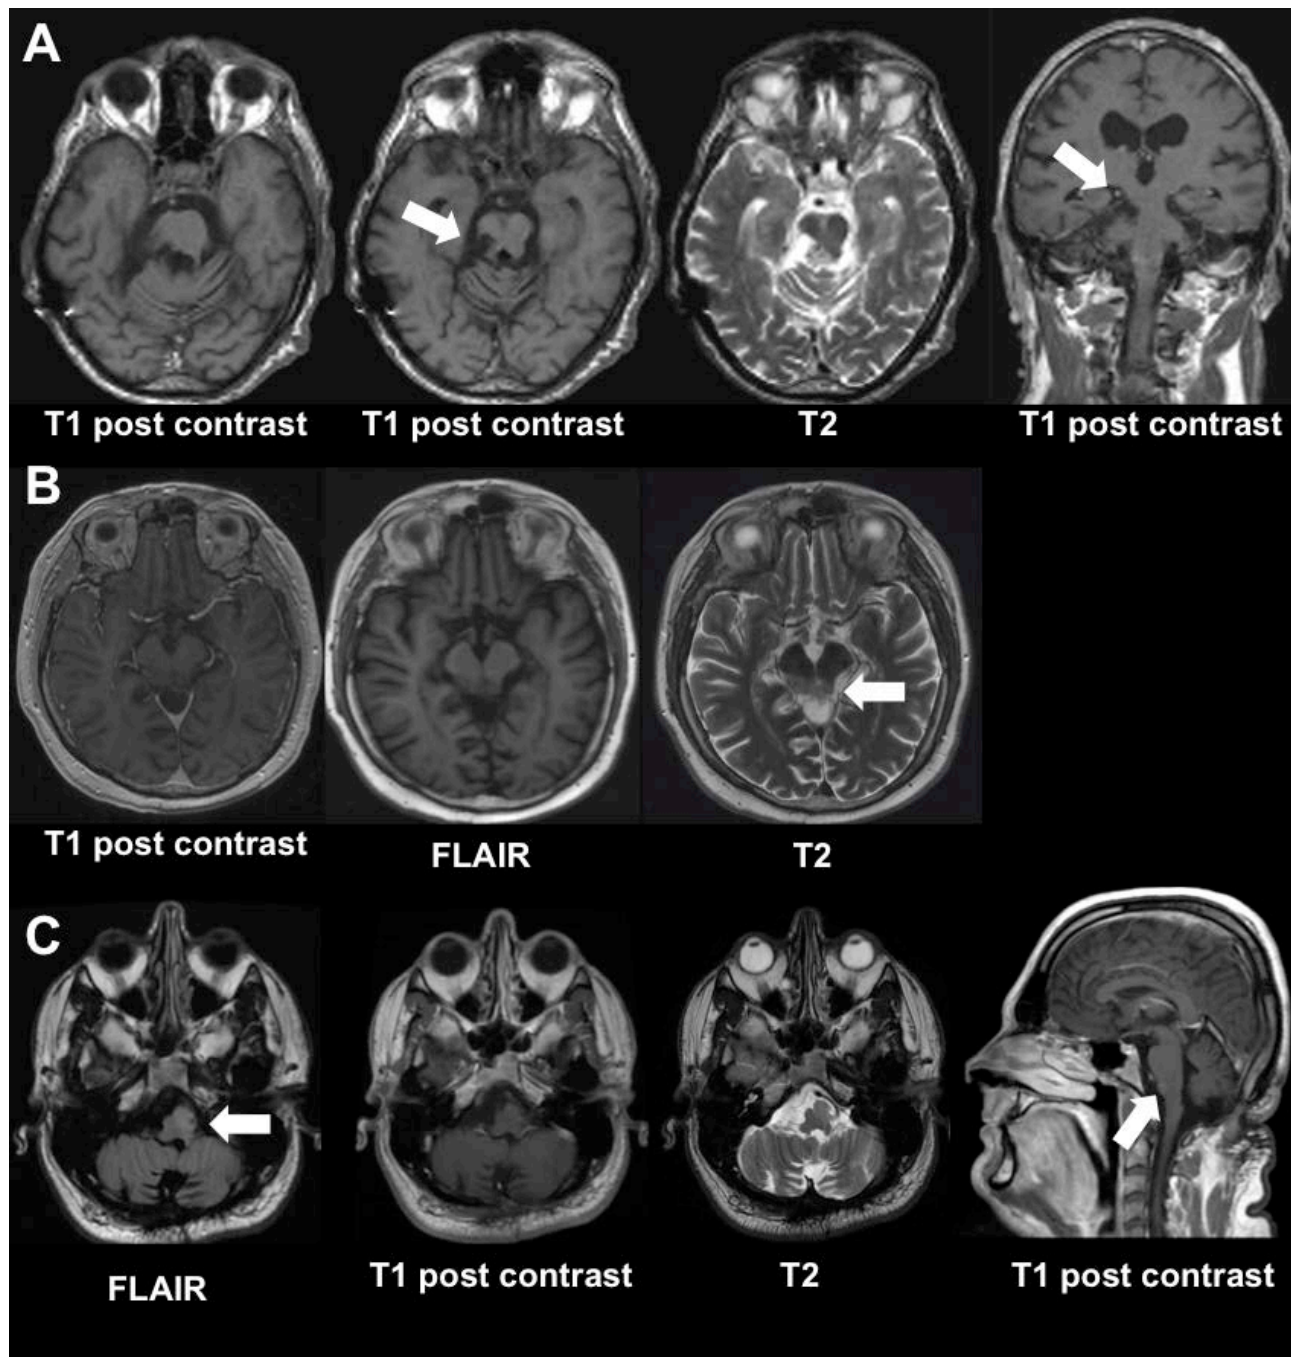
Follow-up MRIs examples of three long-time survivors with pilocytic astrocytomas (WHO grade I) all operated by Prof. Yasargil. A: 44y/m patient with a right pontomesencephalic lesion operated via a right-sided retrosigmoidal approach (06/1986), last follow-up MRI 25years after surgery shows a complete resection without recurrence and a residual left-sided hemiparesis (M4). B: 24y/m patient with dorsal mesencephalic astrocytoma subtotal resected via an infratentorial supracerebellar approach (11/1985), tumor remnant stable on last follow-up MRI 26years after
